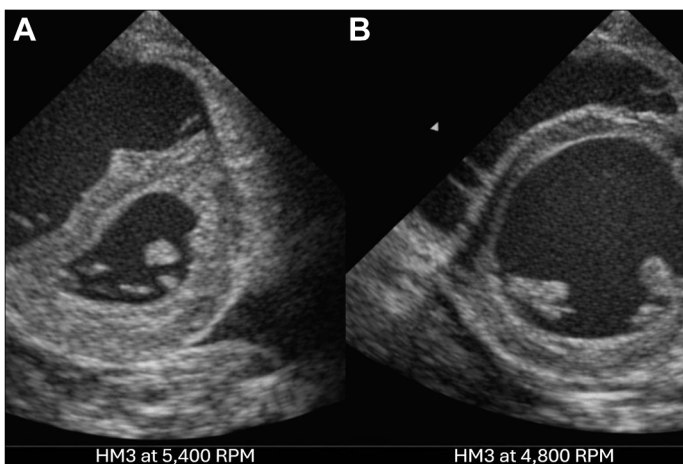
RV failure after LVAD Implantation. Early after LVAD implantation, low-flow alarms prompted multimodal evaluation demonstrating elevated central venous pressure, reduced mixed venous oxygen saturation, low pulmonary capillary wedge pressure, and low LVAD power, flow, and PI. Parasternal short-axis echocardiography showed RV dilation, left ventricular underfilling, and leftward septal shift (A). Following LVAD speed reduction and administration of inhaled nitric oxide, ventricular geometry, and septal position normalized (B). LVAD, left ventricular assist device; PI, pulsatility index; RV, right ventricular.
